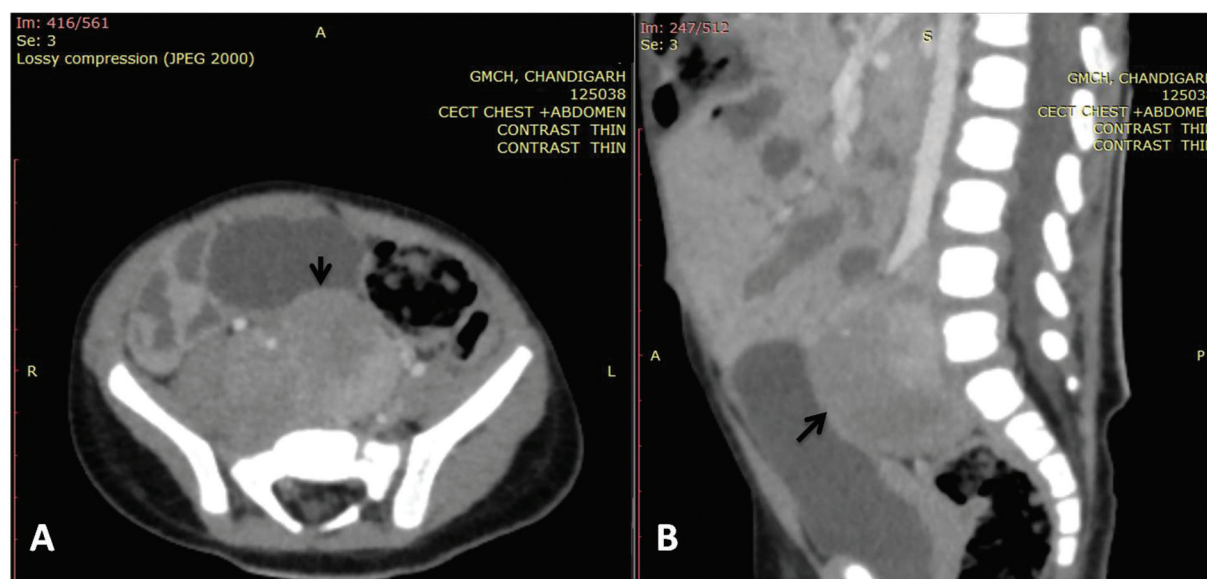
(A) Axial and (B) sagittal image of contrast-enhanced computed tomogram of abdomen showing well-defined heterogeneously enhancing mass lesion (black arrows) in the retroperitoneum, in the midline and on the right side, extending cranially from the level of aortic bifurcation and caudally into the rectovesical pouch in the pelvis till S2-S3 vertebral level displacing the right iliac vessels anterolaterally.
